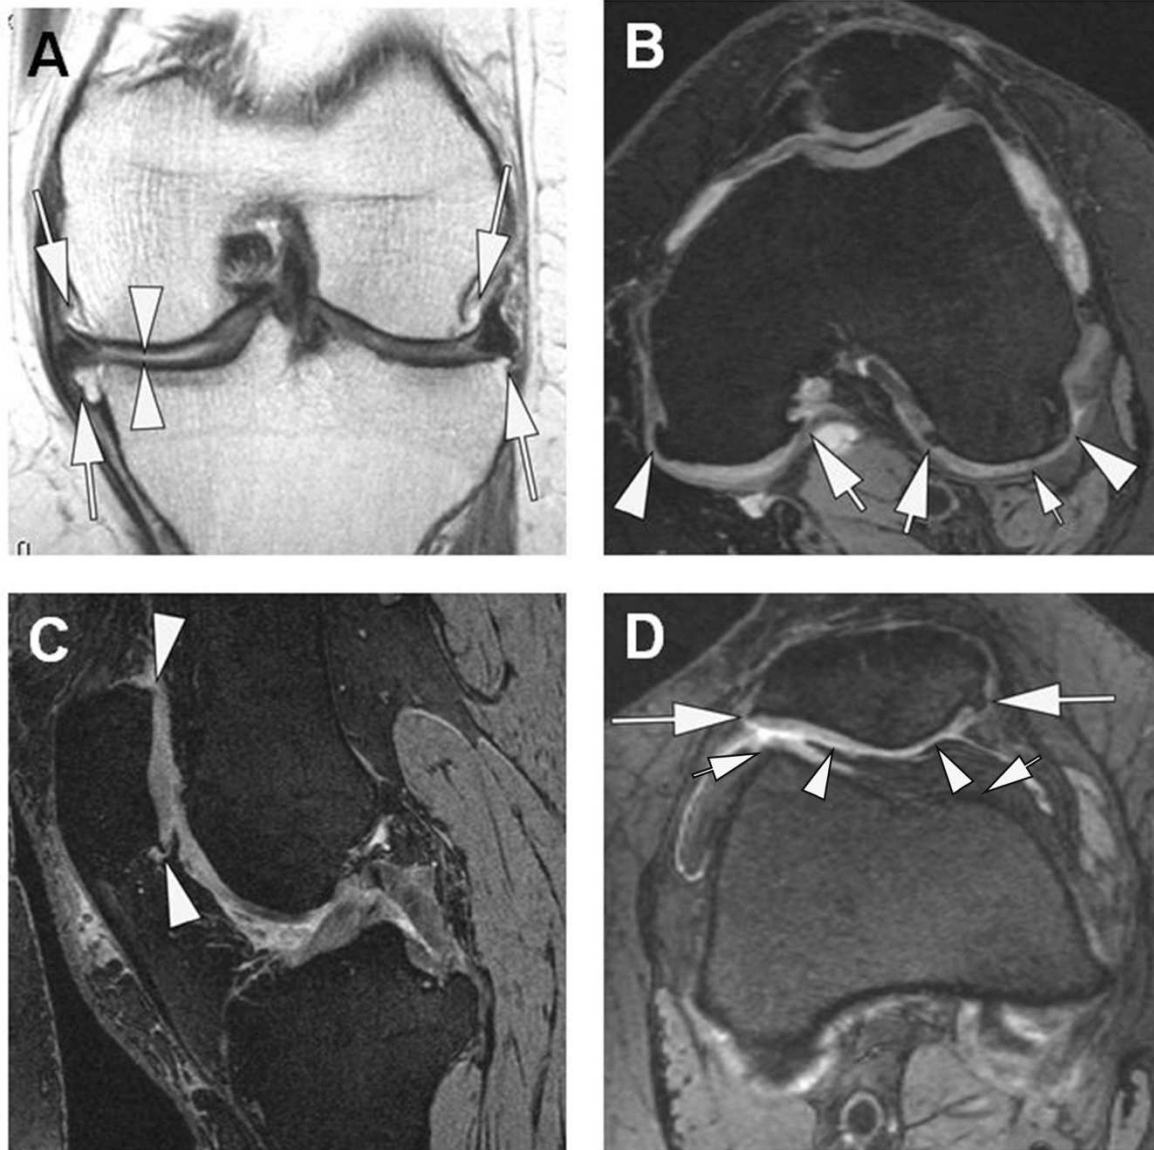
Locations for osteophyte assessment in the current study according to the MOAKS scoring system. A. The MRI locations best reflecting the Kellgren-Lawrence radiographic approach but without the projectional issues of radiography are the medial and lateral femoral and tibial locations (arrows). Note in addition there is diffuse superficial cartilage damage at the medial femur and tibia. B. Axial reformatted image of the sagittal DESS sequence shows the posterior femoral locations for osteophyte scoring. Osteophyte are scored medially and laterally either at the intercondylar location (large arrows) or at the more marginal locations medially and laterally (arrowheads). The larger of the two sites are considered as the MOAKS grade for the posterior femur. Note in addition there is superficial cartilage damage at the lateral posterior femur (small arrow). C. Sagittal DESS image depicts the two osteophyte locations at the superior and inferior patella (arrowheads). D. Axial DESS image shows the medial and lateral patellar locations for osteophyte assessment (arrows). Osteophytes are also assessed at the medial and lateral anterior femur (short arrows). In addition, there is superficial medial and lateral cartilage thinning (arrowheads).
